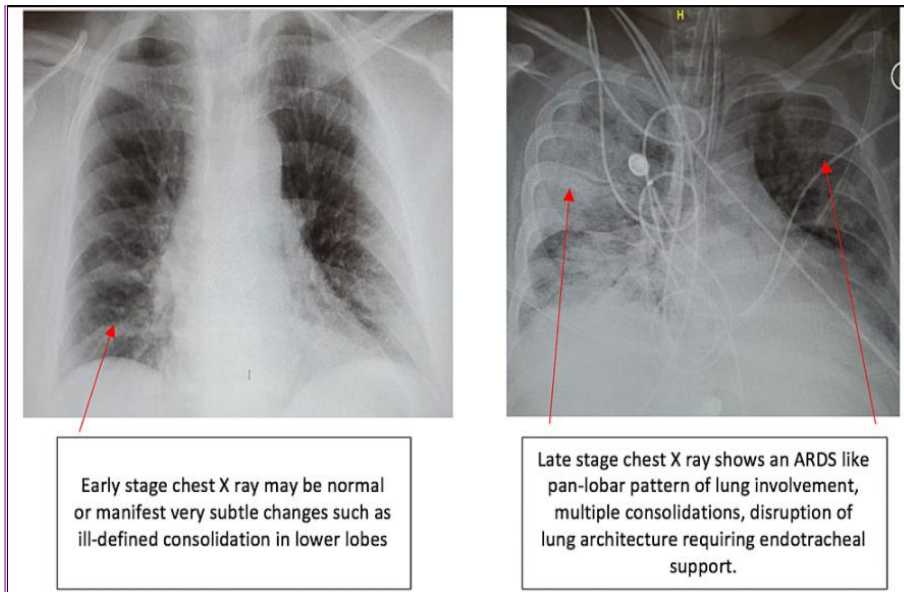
Early and late-stage X-ray findings in patients with COVID-19 infection
